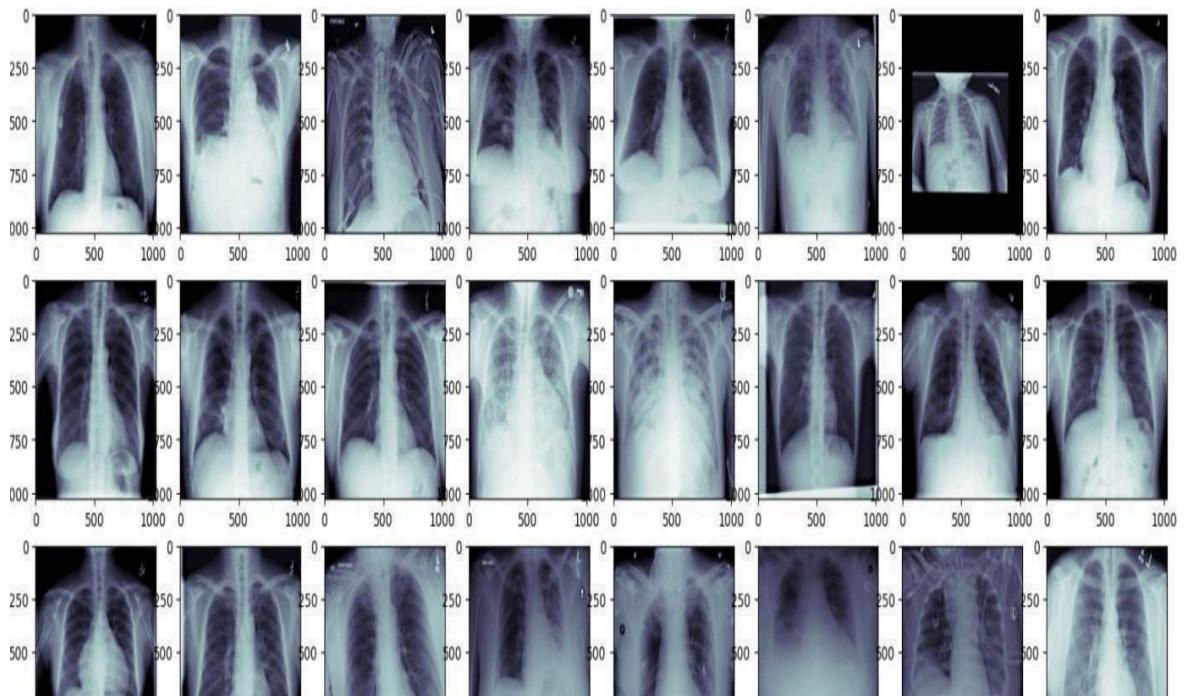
Sample visuals of chest X-Ray images
